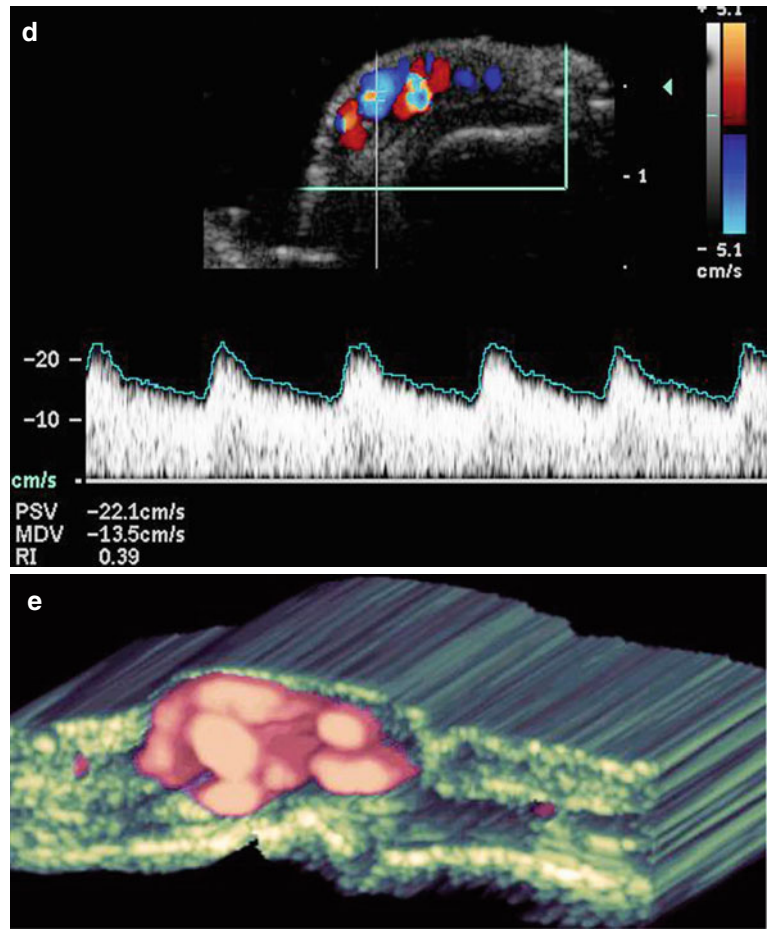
(a–e) High-flow arterial vascular malformation. (a) Clinical image shows erythematous and scaly bump in the right ring finger. (b) Grey scale ultrasound image (longitudinal view) demonstrates oval-shaped anechoic pseudocystic structure in the subcutaneous tissue on top of the extensor tendon and proximal interphalangeal joint. (c) Color Doppler ultrasound image (longitudinal view) shows a nest of vessels
